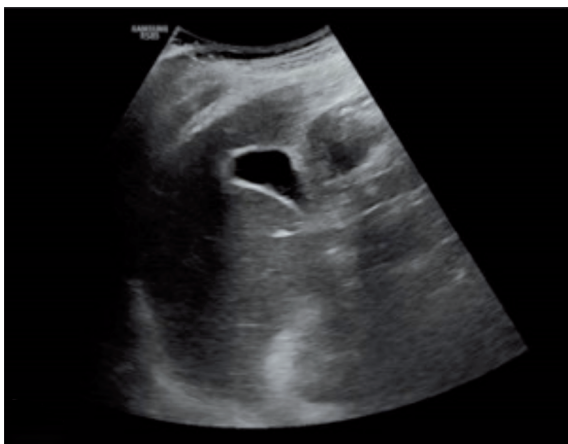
The second abdomen ultrasound examination showed that the peritoneal effusion layer had disappeared.
